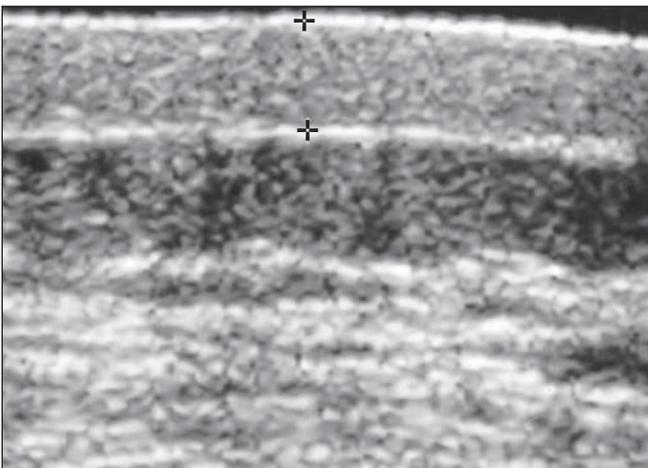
Ultrasonography of the region of atrophic lesion. Decreased dermis thickness, hypoechogenicity and loss of definition between superficial and deep layers can be observed.
